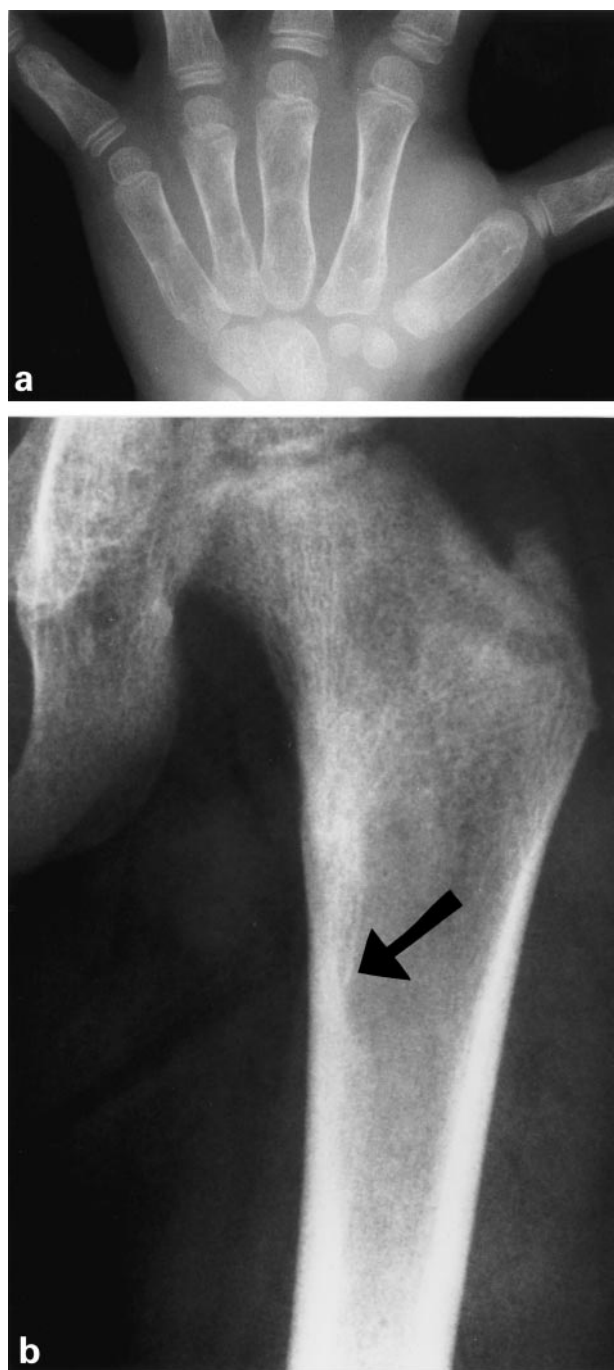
(a) X-ray of the left hand. The third metacarpal bone is wider and poorly modelled relative to the second and fourth; there is poor trabeculation and a ground glass appearance in it and in the little finger metacarpal in particular. These are changes of fibrous dysplasia. (b) X-ray of the left femur. The bone is generally osteopenic, and there is subtle change in the subtrochanter region of the femoral shaft with loss of the normal trabecular pattern centrally and early endosteal scalloping medially (arrow). Early stress lines are developing above the area of lucency.
